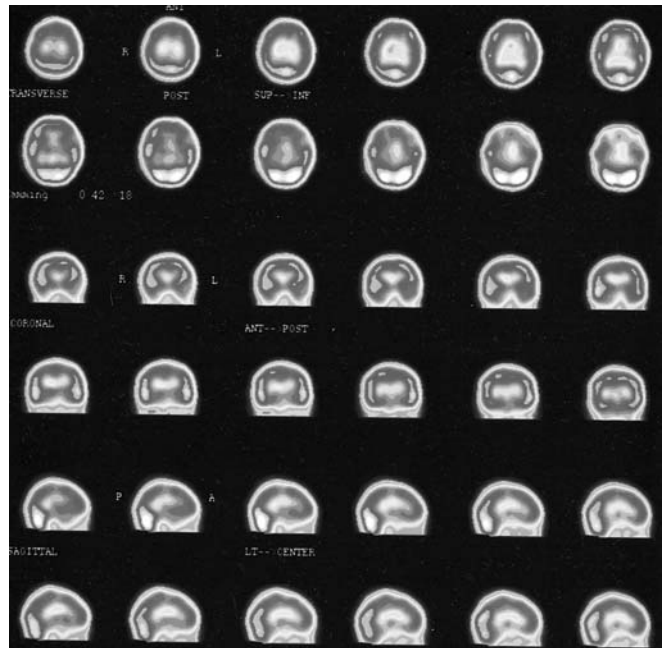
Brain SPECT of an SLE patient showing the diffuse pattern of hypoperfusion
